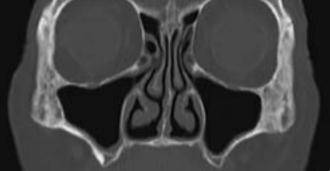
a) Coronal bone window scintigraphy reconstruction: increase in the size of the maxillary and frontal sinuses due to hyperpneumatization in a patient with acromegaly. b) Coronal bone window scintigraphy reconstruction in a patient without acromegaly: note the normal size of the maxillary sinuses in comparison with image a).
